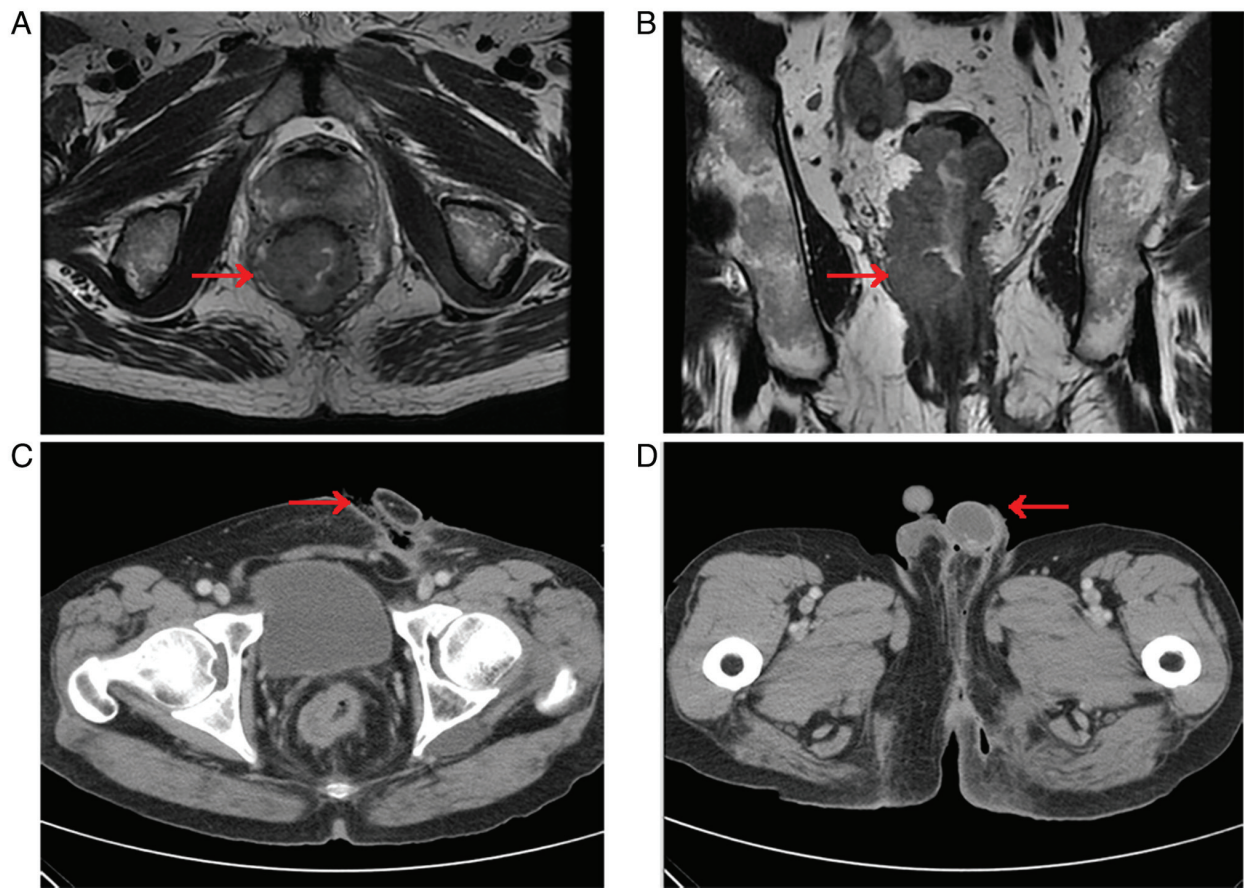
Preoperative imaging examinations of the patient. (A) Pelvic contrast-enhanced MRI revealed a rectal mass and it was almost circumferential. (B) The right musculus levator ani was invaded in MRI. (C) Abdominal CT indicated the left inguinal wound. (D) Left scrotal defect was found in pelvic CT. MRI, magnetic resonance imaging; CT, computed tomography.
